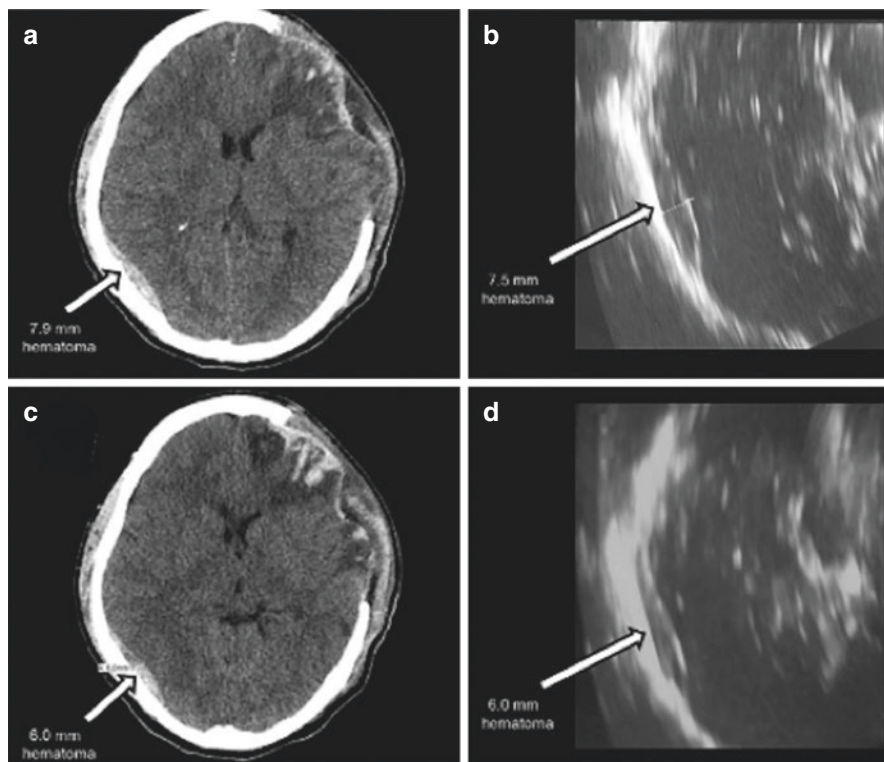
Brain CT-scan and TCCS (B-mode): (a) CT-scan showing persistent diffuse edema and epidural hemorrhage, approximately 7.9 mm diameter; (b) TCCS showing an epidural hematoma with 7.5 mm diameter; (c) CT- scan showing an epidural hematoma with 6 mm diameter; (d) TCCS showing a 6 mm diameter epidural hematoma (EDH). (Courtesy: Lacerda FH, Rahhal H, Soares LJ, Ureña FDRM, Park M. *Rev. Bras Ter Intensiva*. 2017;29(2):259–260)
